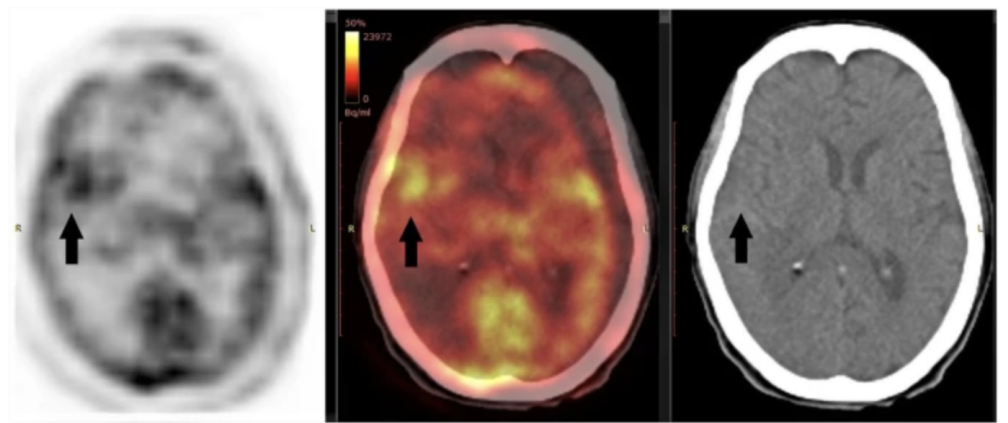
The axial CT (right), fused (middle), and PET (left) brain images of brain-included whole-body FDG PET/CT showing right temporal lesion (black arrow) that appears as a subtle hypodense area in CT with max SUV 8.0. The primary tumor turned out to be colon adenocarcinoma
